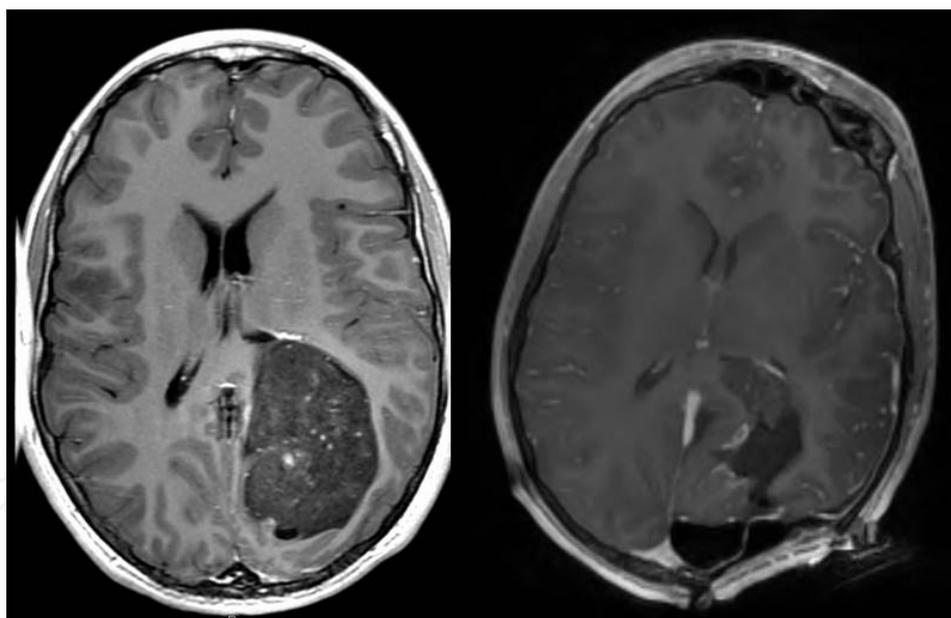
Axial T1-weighted preoperative and intraoperative scans showing low-grade non-enhancing tumor with residual tumor positioned next to atrium on intraoperative scan, that was subsequently resected.
